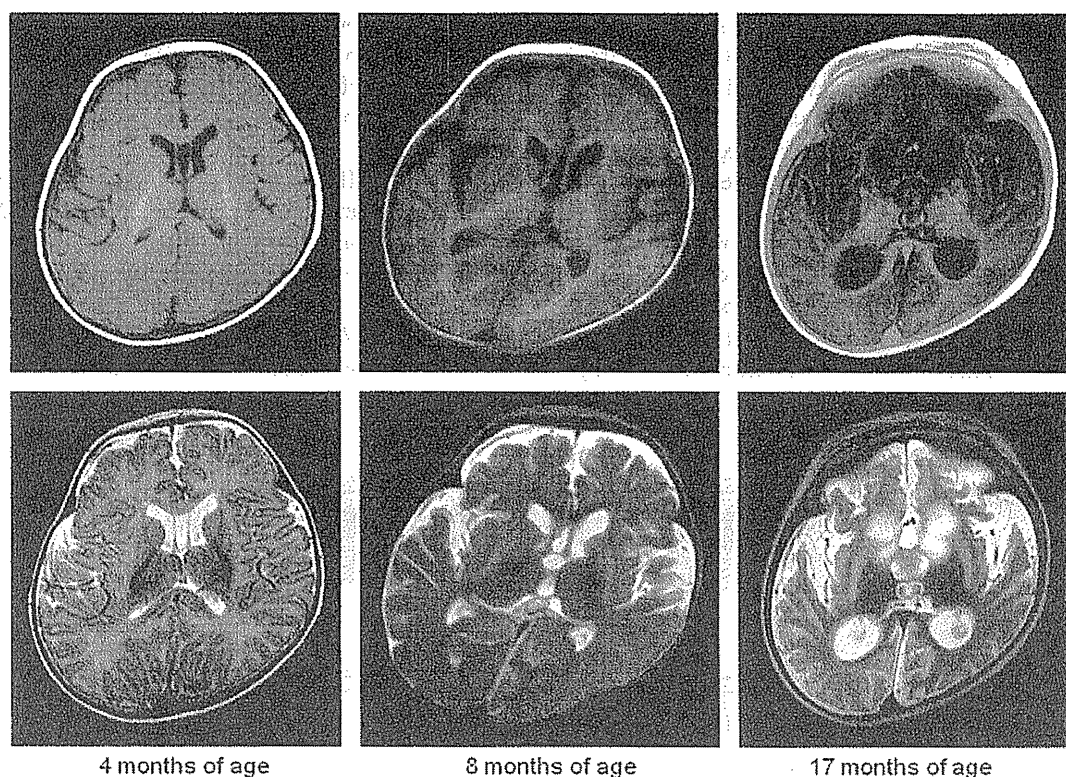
MRI findings. Top: T1-weighted images, Bottom: T2-weighted images. Left: at 4 months of age, no remarkable abnormalities were observed. Middle: at 8 months of age, abnormal high intensities were observed in the bilateral putamina and caudate nuclei on T2-weighted images. Right: at 17 months of age, severe caudate nuclei atrophy, high intensities on T2-weighted images in the bilateral putamina, and marked ventriculomegaly and enlargement of extra-axial space were seen.
